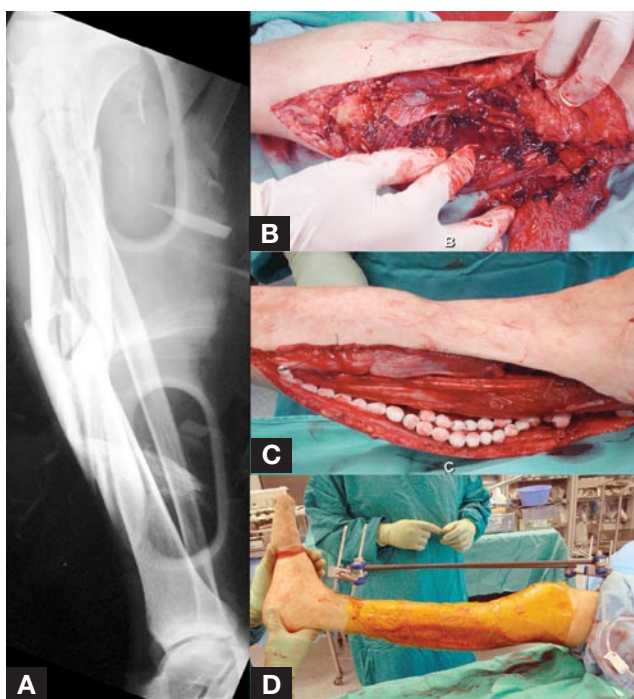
(A) Lateral radiograph of type IIIC open tibia fracture in 77-year-old man. (B) Clinical photograph of open wound before débridement. (C) Clinical photograph of wound after débridement and placement of string of antibiotic beads. (D) Clinical photograph after external fixation and placement of impermeable dressing around wound.
